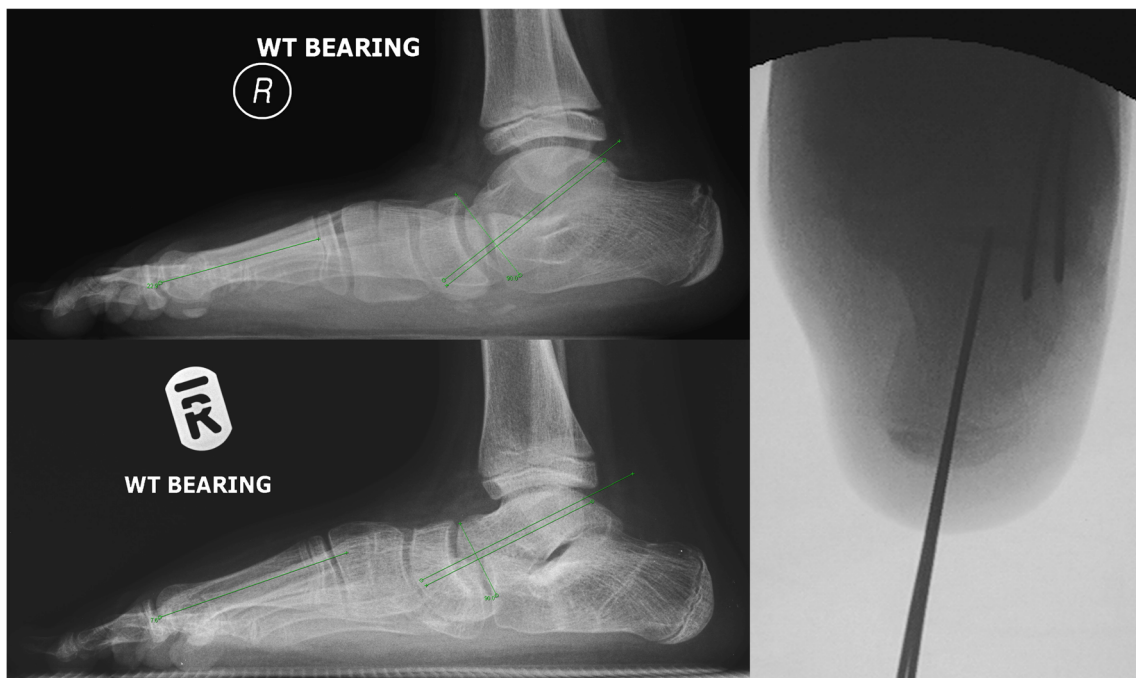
Patient A5. Top left, pre-operative weight-bearing lateral foot X-ray showing Meary's angle of -22.90° . Bottom left, post correction weight-bearing lateral foot X-ray showing Meary's angle of -7.60° (15.30°
